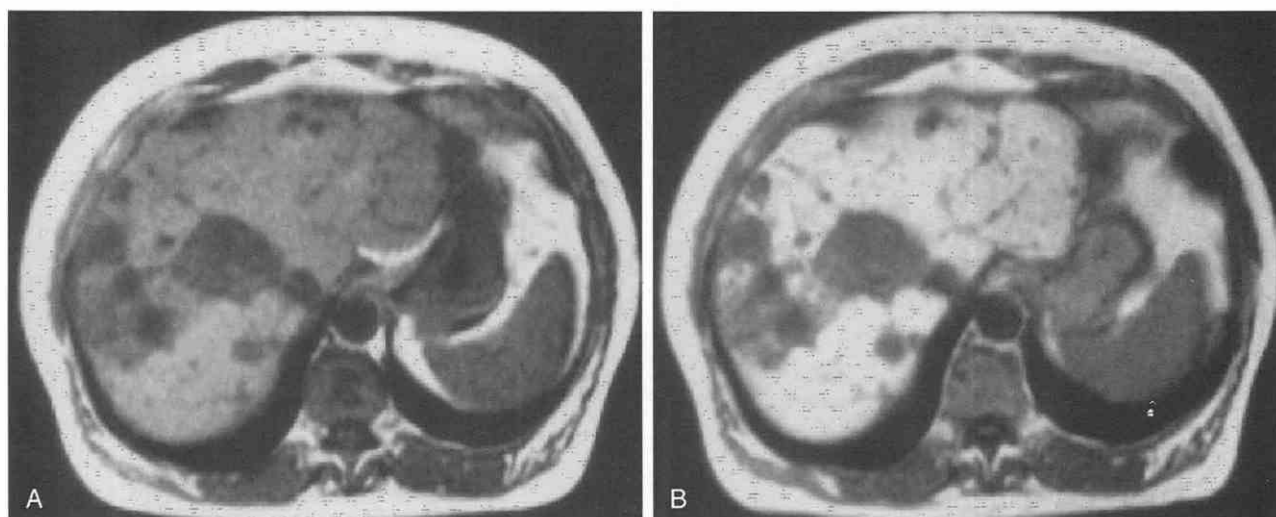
Liver metastases. *A*, Unenhanced T1-weighted image demonstrates multiple hepatic lesions. *B*, T1-weighted image after manganese-DPDP administration shows enhancement of the normal liver with improved conspicuity of the proven liver masses.
